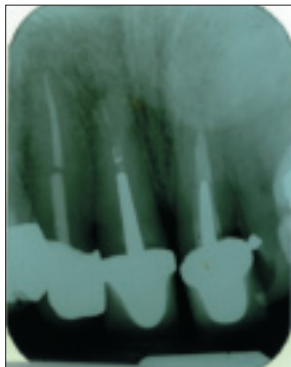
Preoperative radiograph. The cast post of tooth 11 is leaking, and the root canal of this tooth is deficient.
